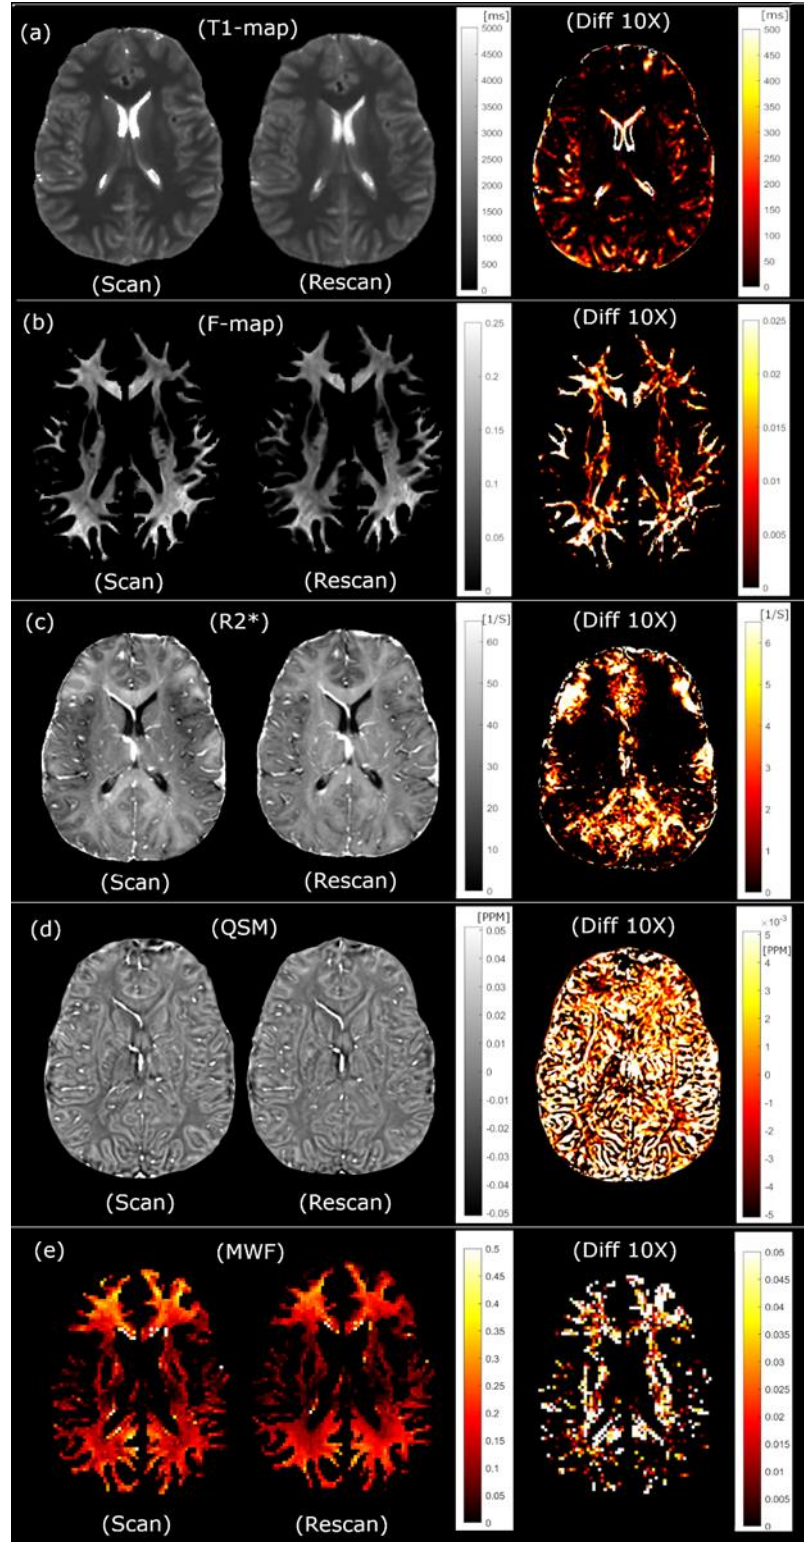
Representative quantitative MRI maps in scan and rescan experiments and the corresponding difference map (Diff) in a single subject: (a) T1-map (using all TIs), (b) qMT F-map, (c) R2*, (d) QSM, and (e) MWF maps. The difference map is zoomed in (10x).
